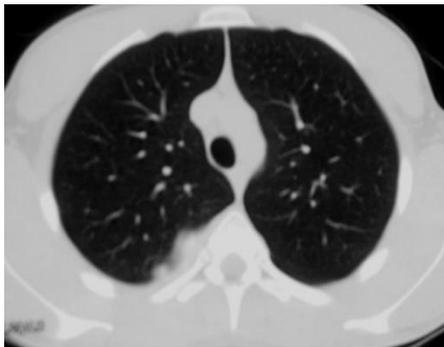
CT scan of the thorax, space occupying process in the right costo-vertebral space.
